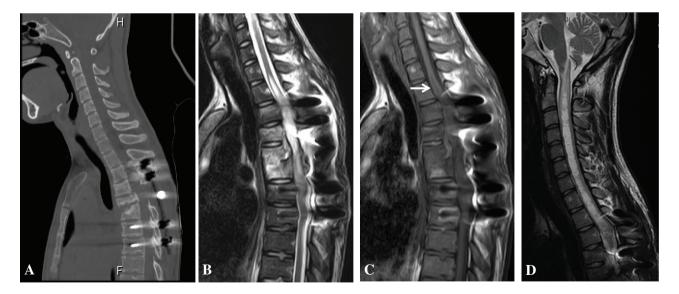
Imaging studies after posterior decompression and fusion at another hospital. Computed tomography scan shows that spinal canal decompression was obtained at the T5 level but with residual stenosis between the T4 lamina and the retropulsed posterior wall of the T5 vertebral body (A). T2-weighted MRI 2 weeks after the injury shows swelling of the spinal cord above the T4 level with intramedullary hyperintensity at the T2-T4 level (B) while T1-weighted image shows a small syrinx at the T2 level (arrow, C). MRI at 4 months shows syrinx extending from the T3 to the C1 level, with a conical-shaped base at the T3 level (D). MRI: magnetic resonance imaging
